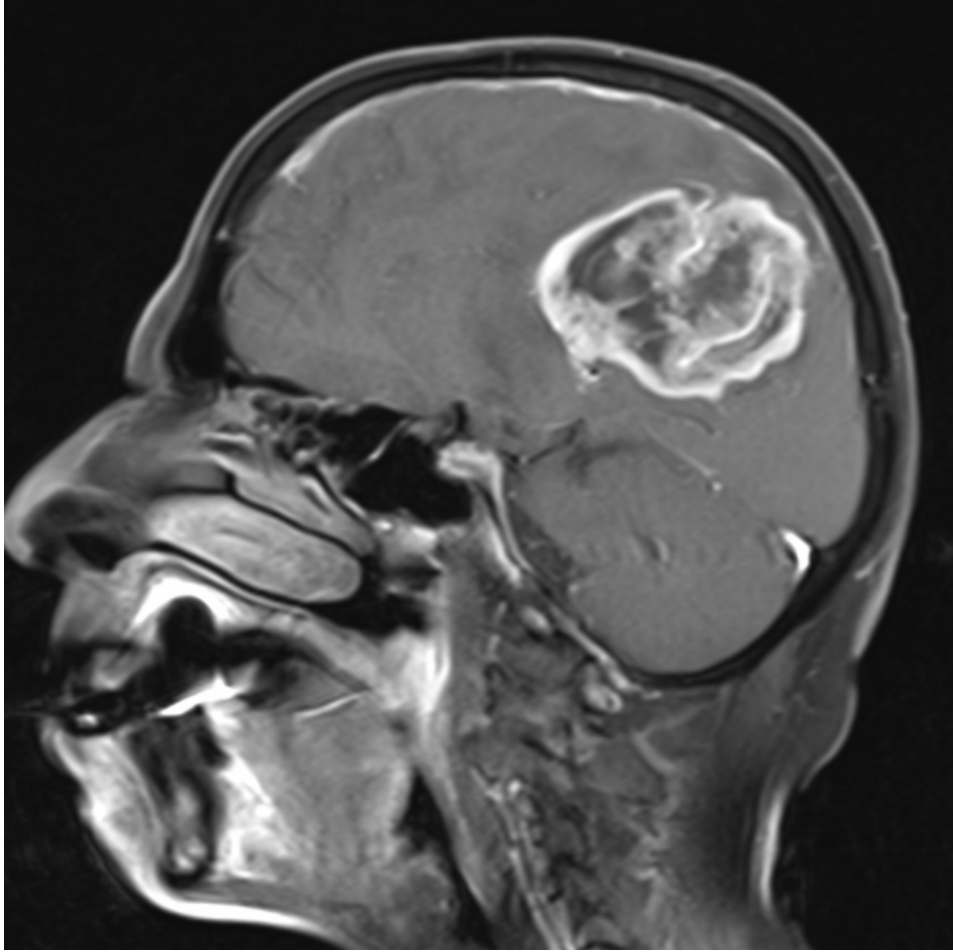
MRI brain – S239/19, Parietal glioblastoma (IDH1 & EGFR negative)– ring enhancement present.
